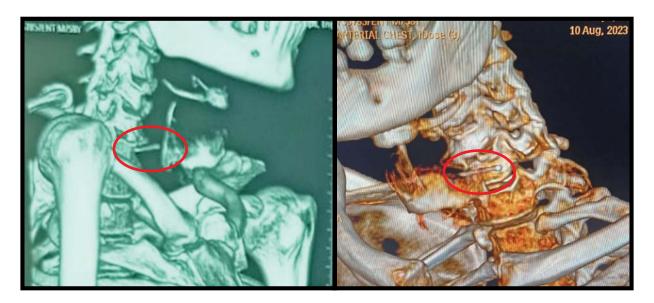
and 2B: 3D reconstructed Computered tomography (CT) view of the Foreign body (red outlined) in the prevertebral space with a close relation to the cervical vertebral coloumn (C5,6 level).
